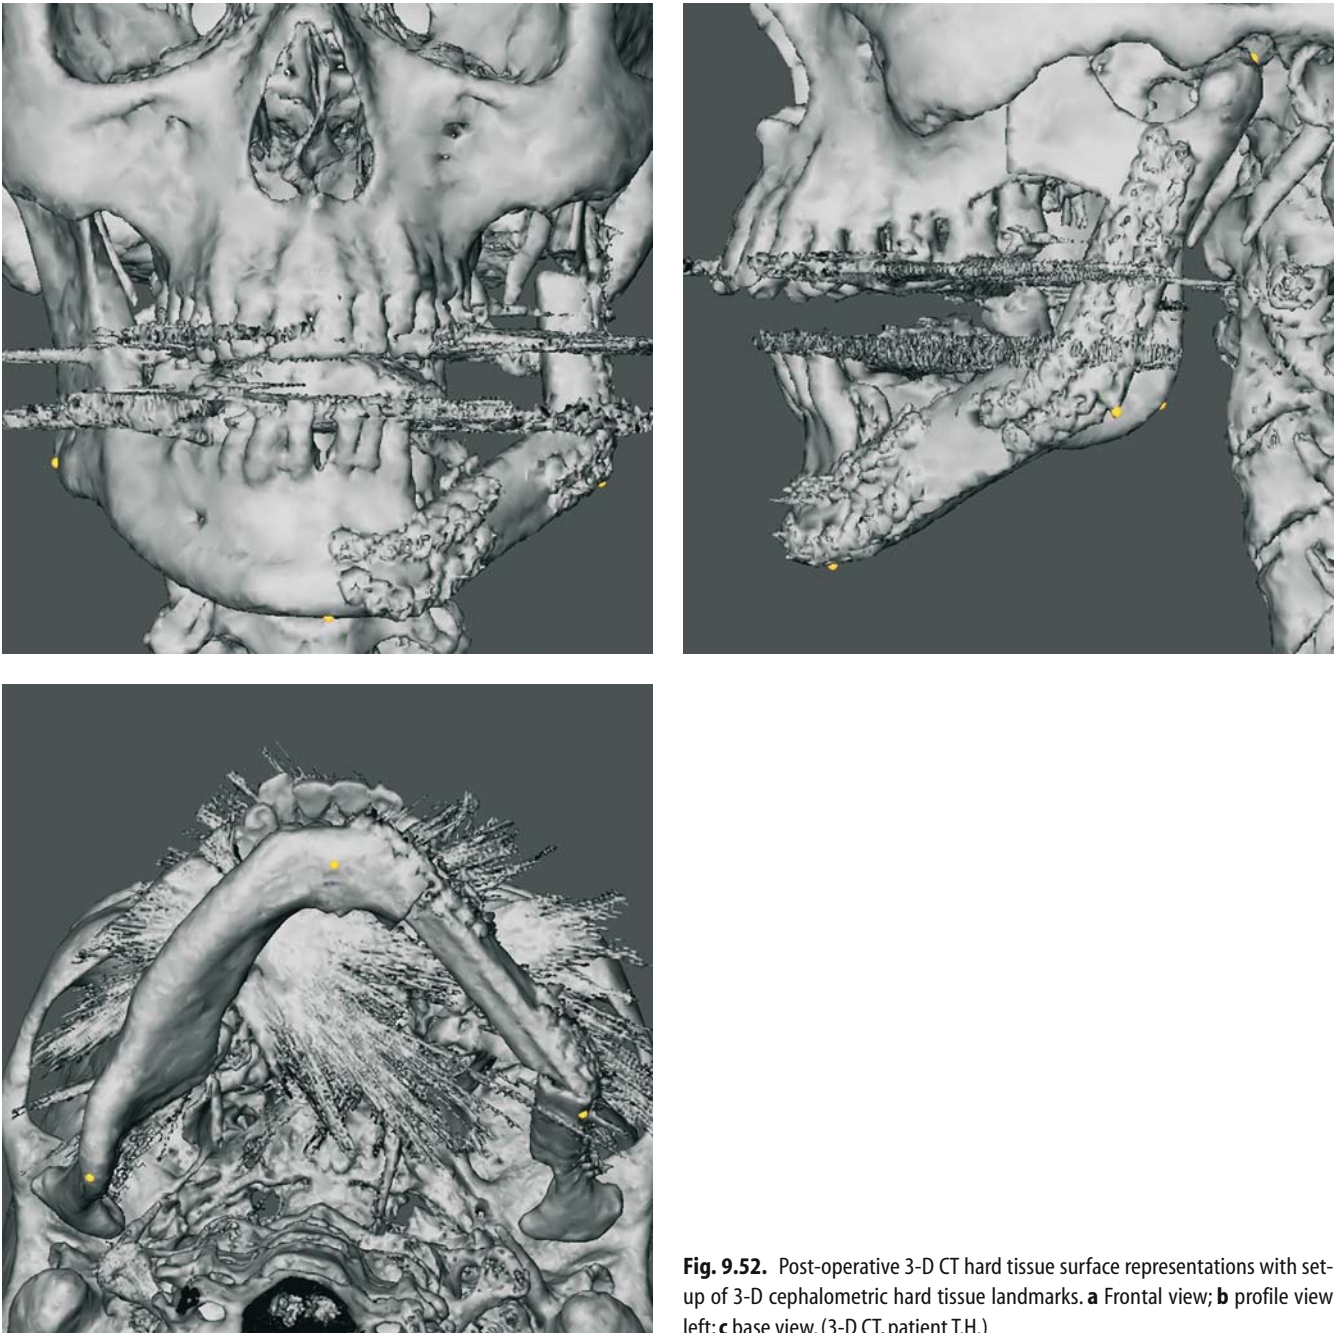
Post-operative 3-D CT hard tissue surface representations with set-up of 3-D cephalometric hard tissue landmarks. a Frontal view; b profile view left; c base view. (3-D CT, patient T.H.)
